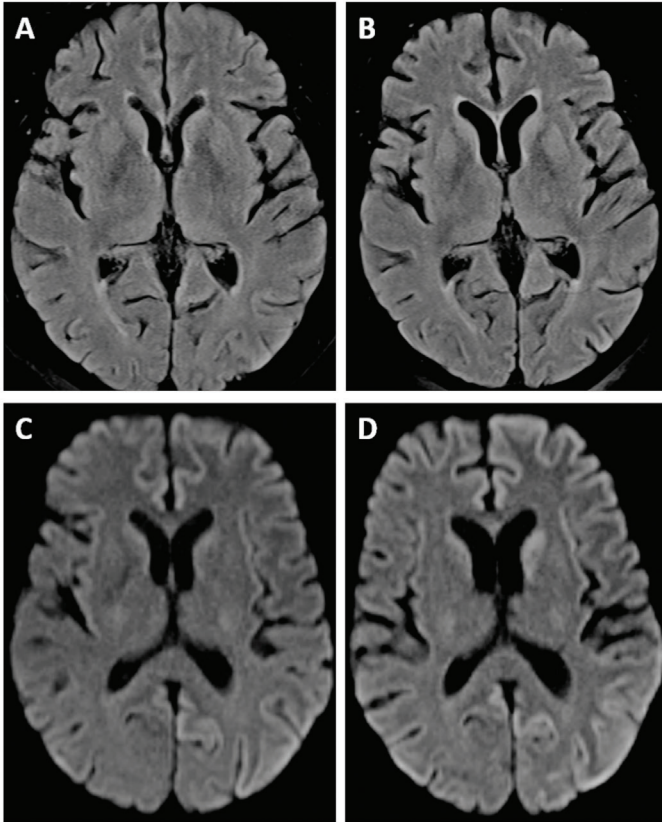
Brain magnetic resonance imaging (MRI) revealed hyperintensity in the left parietal cortex (A, C). Follow-up MRI presented very suggestive radiological signs of Creutzfeldt-Jakob disease (B, D).
